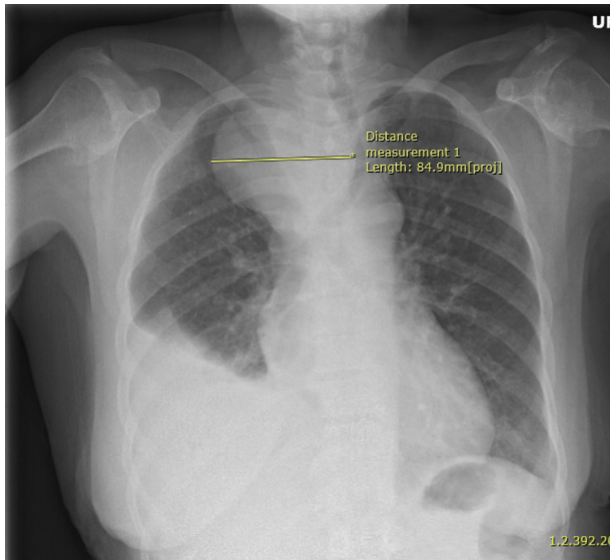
Presenting chest radiograph showing a paratracheal mass.
